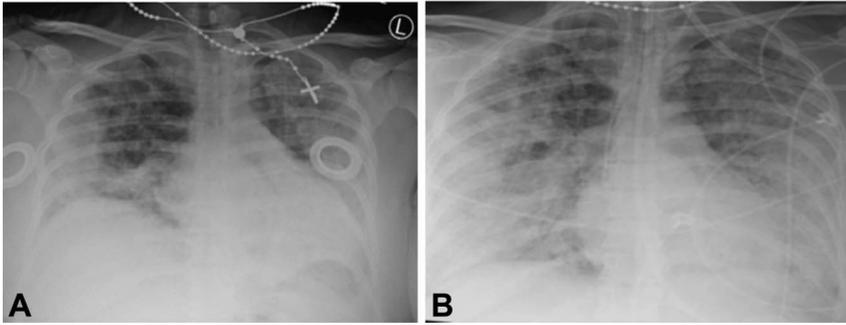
A. Chest radiograph obtained during the initial emergency department evaluation. B. Postpartum chest radiograph on intensive care unit admission.
